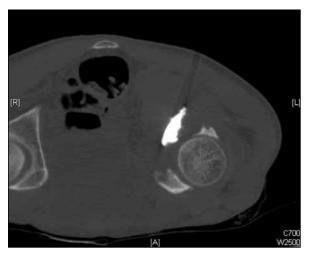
Post-treatment computed tomographic pelvis showing satisfactory cement injection into the metastatic lesion
